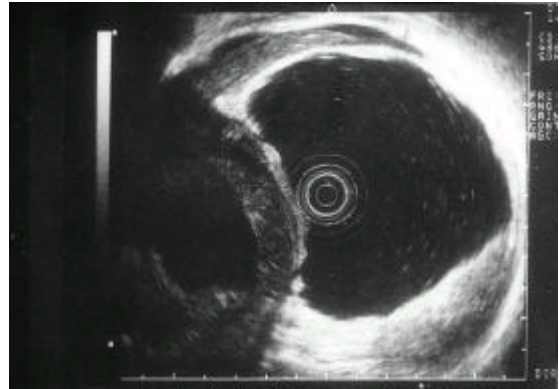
Endoscopic ultrasonography showed a large cystic mass near the stomach and liver. The wall echo of the stomach near the mass was normal.
